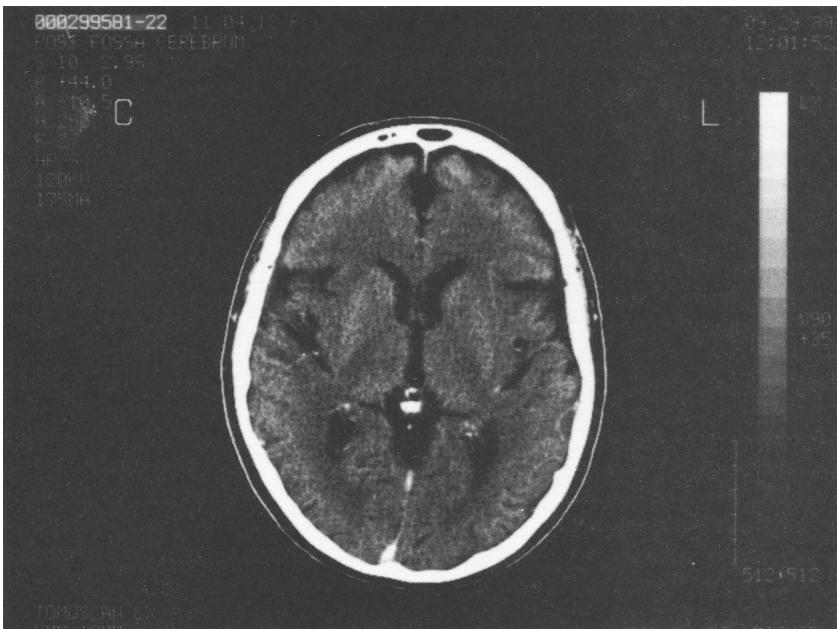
A 512 x 512 pixel CT Image of the brain Note that the increased number of pixels yields improved images. (Photo Courtesy of Philips Medical Systems.)
